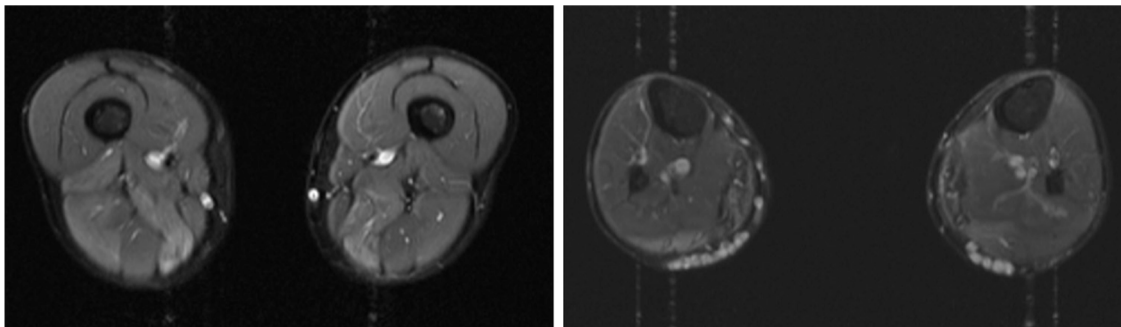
MRI scan. STIR sequence revealing hyperintensity in the biceps femoris, semimembranosus, and gastrocnemius muscles.
